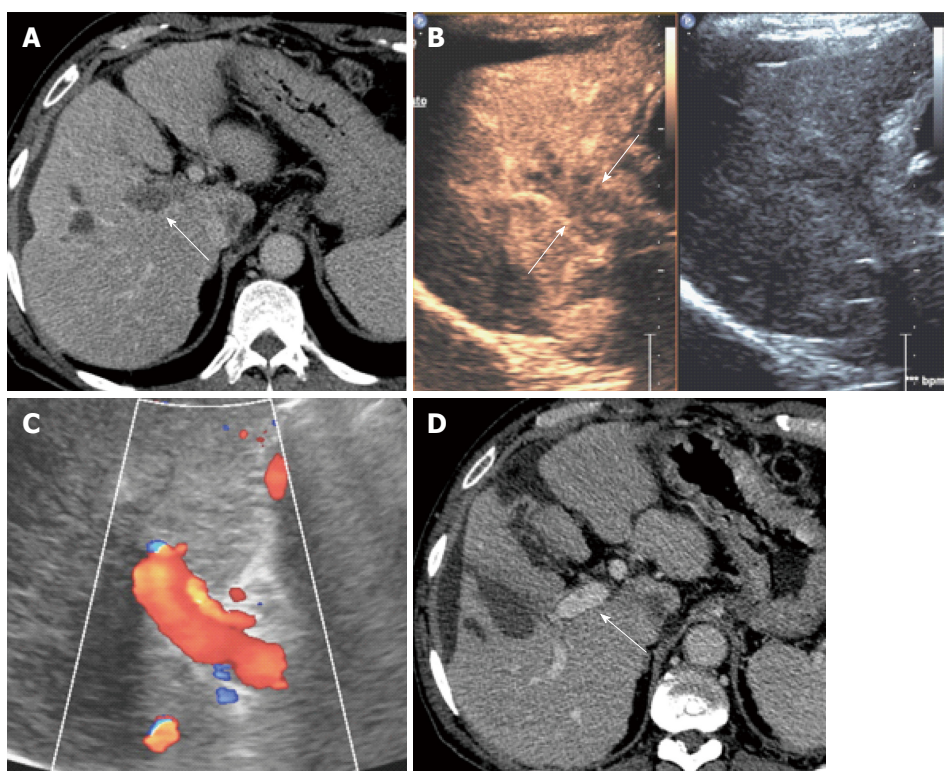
M.D.S. 64 years hepatitis C virus related cirrhosis. A: On september 2014 computed tomography (CT) showed complete malignant thrombosis of right portal vein (arrows); B: Pretreatment contrast enhanced ultrasound showed diffuse enhancement of the thrombus (arrows) consistent with malignant thrombosis; The patient underwent electrochemotherapy with insertion of 6 electrode-needles and *i.v.* Bleomycin bolus; C: Three months monthly color-Doppler ultrasound control showed complete patency of the right portal vein; D: Persistent patency of the right portal vein (arrows) and absence of local recurrence was confirmed at 3, 9, 15 mo follow-up CT control.
